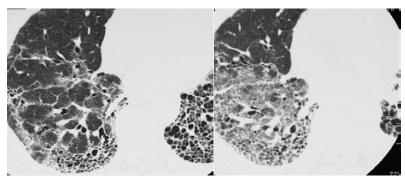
An example of a baseline HRCT appearance of IPF, with a subpleural and a basilar predominant reticular infiltrate along with honeycombing fibrosis (left). An example of the same patient presenting with an IPF exacerbation, now with new ground glass infiltrates on the background of the chronic fibrosis (right)³³
